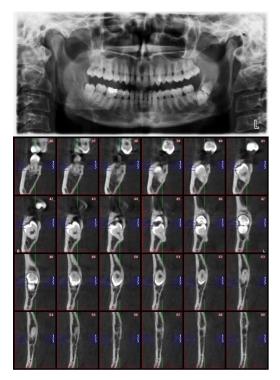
Orthopantomograph and CBCT of the patient revealing kissing molars.
